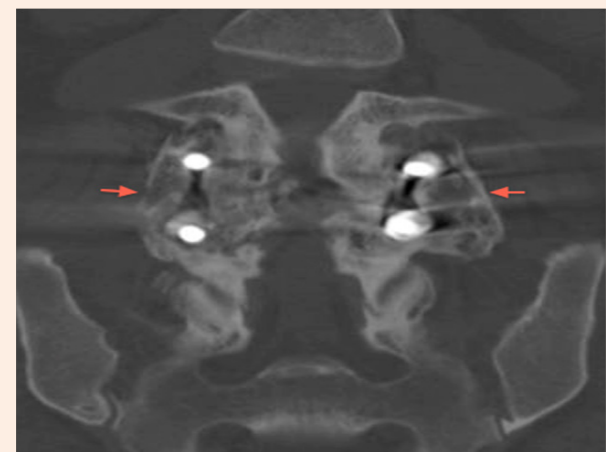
CT evidence of bridging fusion mass.
